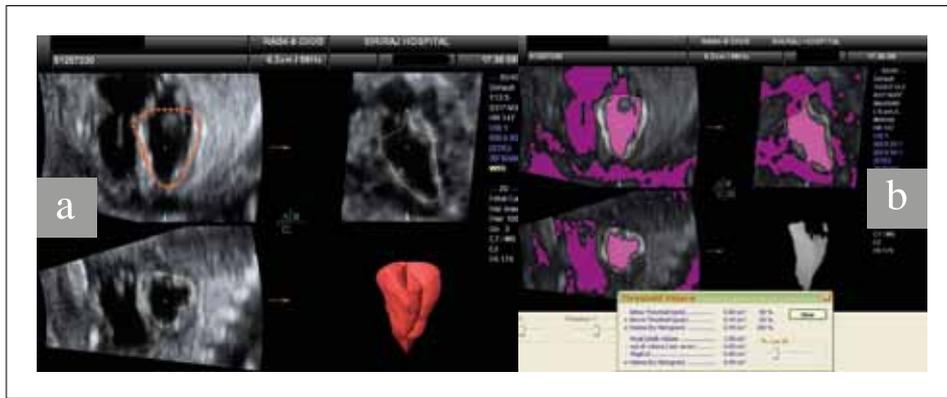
Assessment of fetal cardiac function by 3D ultrasound.
